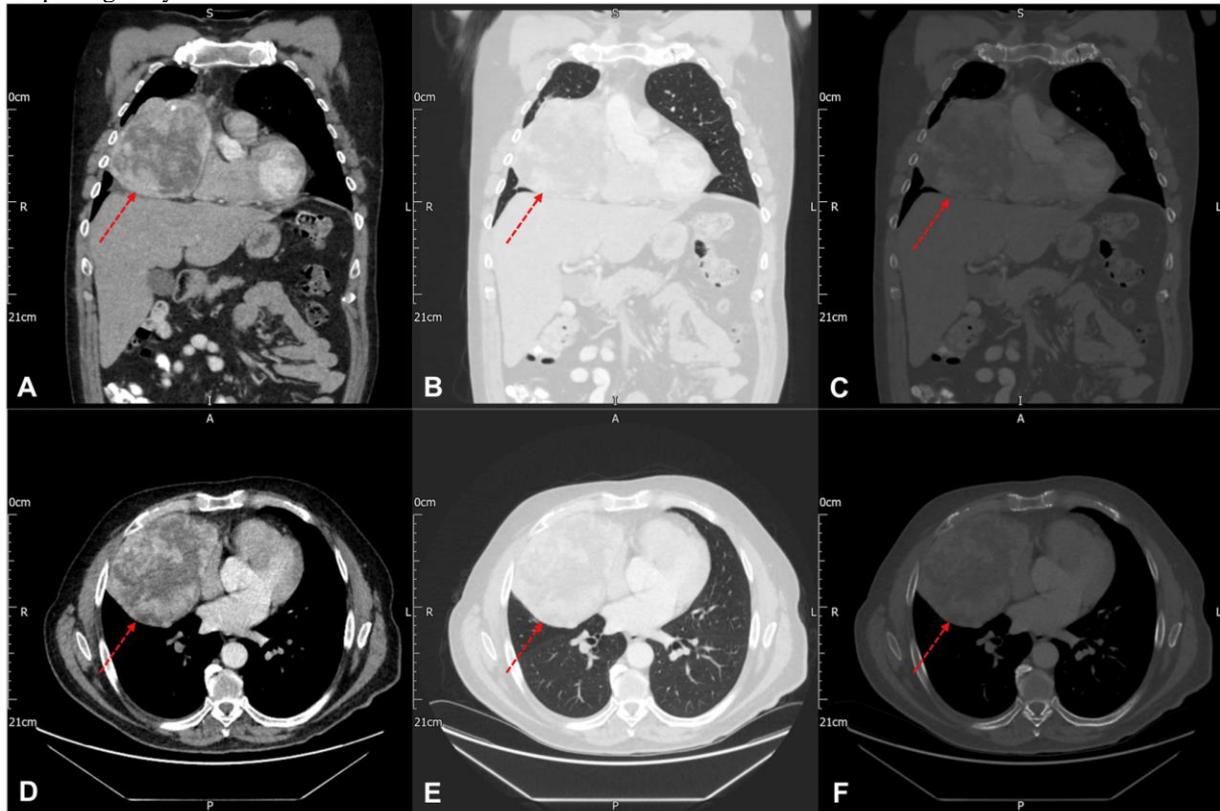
A contrast-enhanced computed tomography (CT) scan showing a large, globular, and heterogenous mass within the right hemithorax (red arrow). Panel A/D shows the mediastinal window, demonstrating the chest wall and pleura. Panel B/E shows the lung window, demonstrating the lung parenchyma in detail, including the pulmonary vasculature. Panel C/F shows the bone window.
